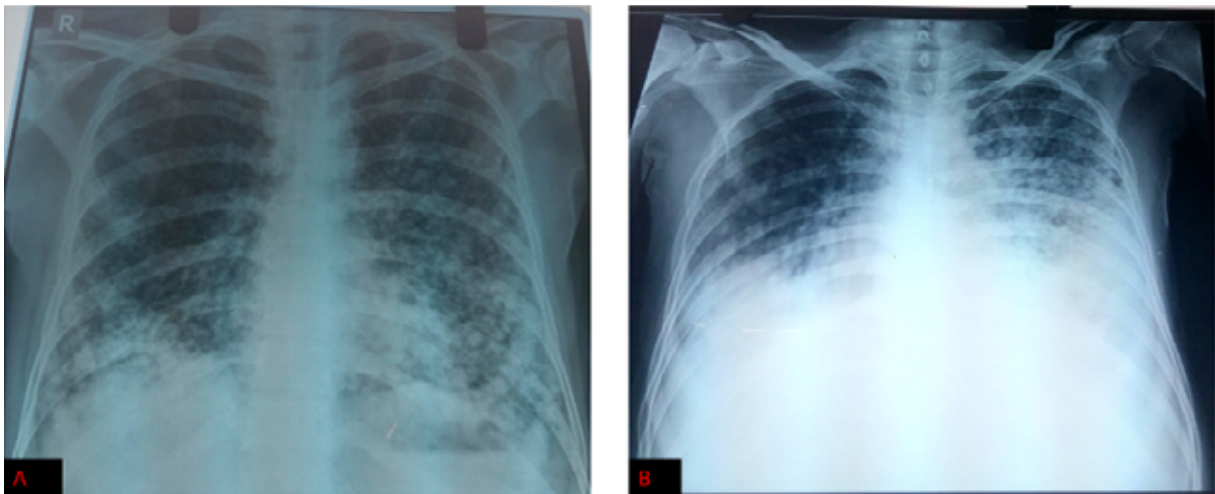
A) Chest radiograph showing near symmetrical fine nodular opacities, more in mid and lower lung zones. No obvious mediastinal, pleural, hilar or bony abnormality is present. B) Chest radiograph showing multiple small nodular opacities in bilateral lung fields. Lesions appear to have increased and are denser in comparison with previous radiograph
